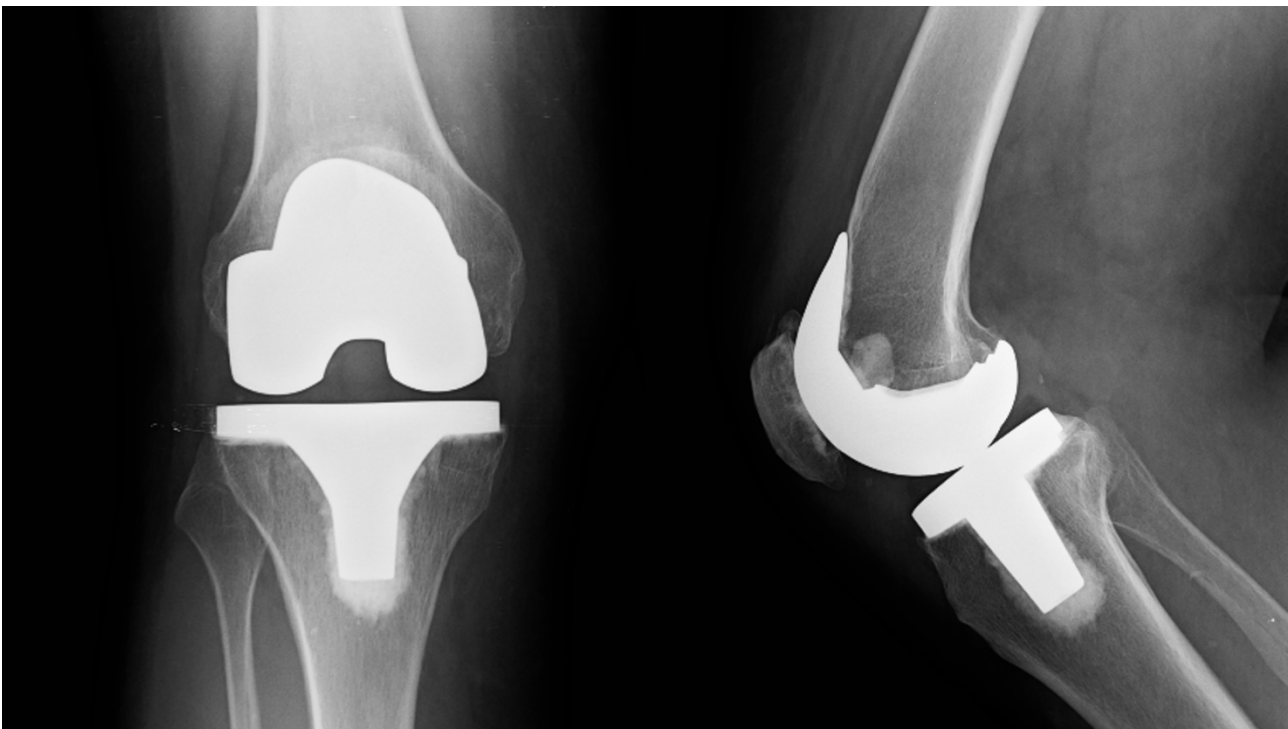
X-ray of a PS knee prosthesis with traditional design
